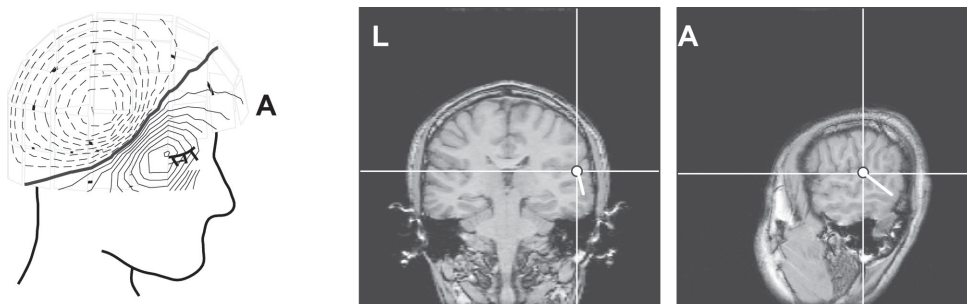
An isocontour map and a source location in subject S2, for session-1, number of clicks = 64. (a) A typical isocontour map. The dashed lines indicate flux into and the solid lines indicate flux out of the head. Contour step = 50 ft/cm. (b) An ECD overlaid on the subject's magnetic resonance image (MRI). L: Left, A: Anterior.
